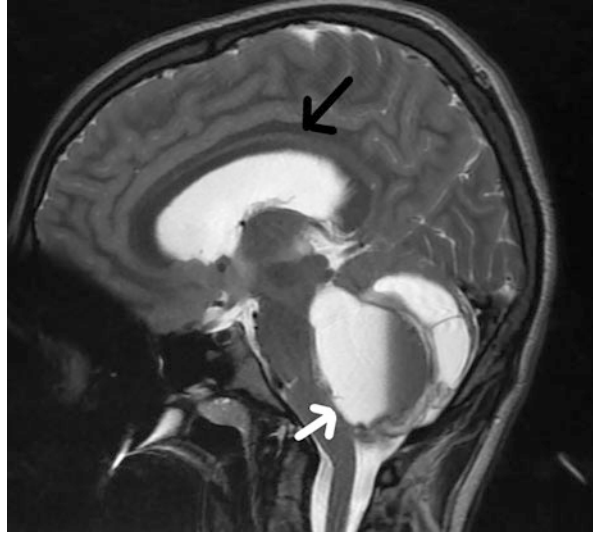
Sagittal T2 weighted MRI of the same child noting significant hydrocephalus (black arrow) and mass in the posterior fossa that is compressing the brain stem and fourth ventricle (white arrow)
